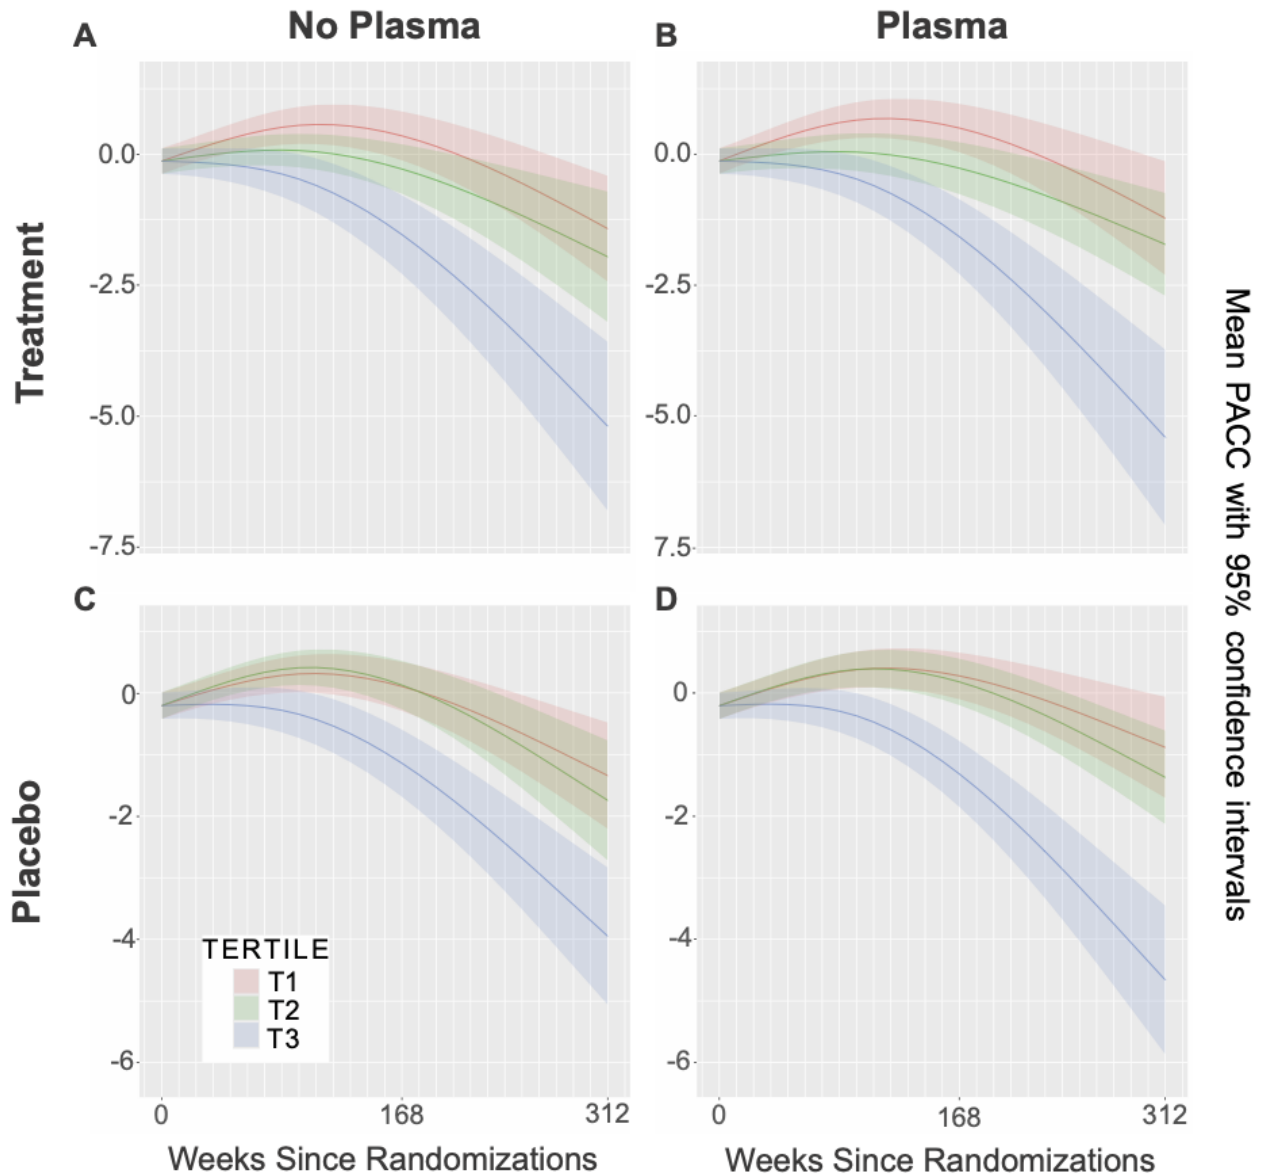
Held-out A4 subjects stratified according to tertiles of average temporal meta ROI SUVR derived from synthetic tau PETs generated by the CoMA-UNet including plasma ptau-217 as a covariate (panels B and D), and in the absence of plasma ptau-217 as a covariate (panels A and C). Panels A and B display PACC score trajectories for each tertile among subjects that received treatment. Panels C and D display PACC score trajectories for each tertile among control (placebo) subjects.
